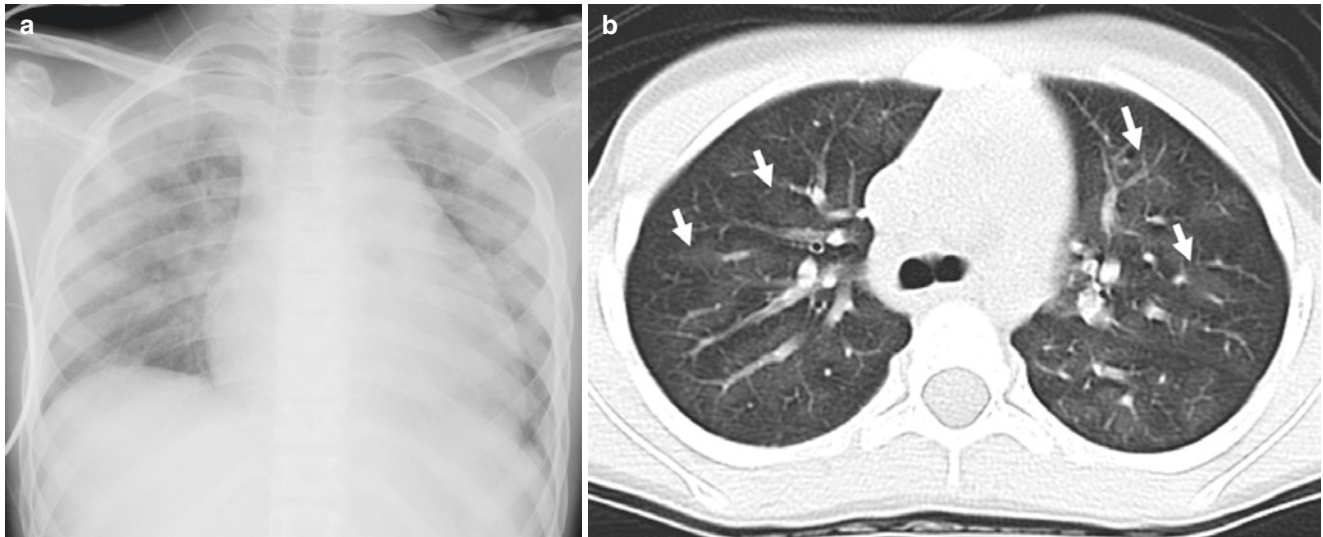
Nine-year-old girl with idiopathic pulmonary hypertension who presented with chest pain. (a) Frontal chest radiograph shows mild diffuse opacities in both lungs. (b) Axial lung window CT image shows
